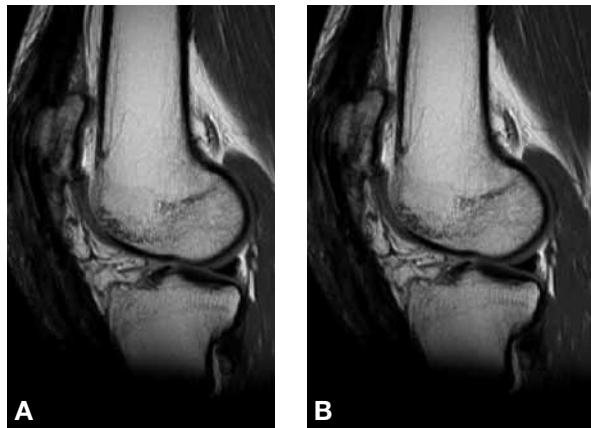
Magnetic resonance imaging 7 months after surgery shows (A) an intact extensor mechanism with (B) incorporation of the graft.
